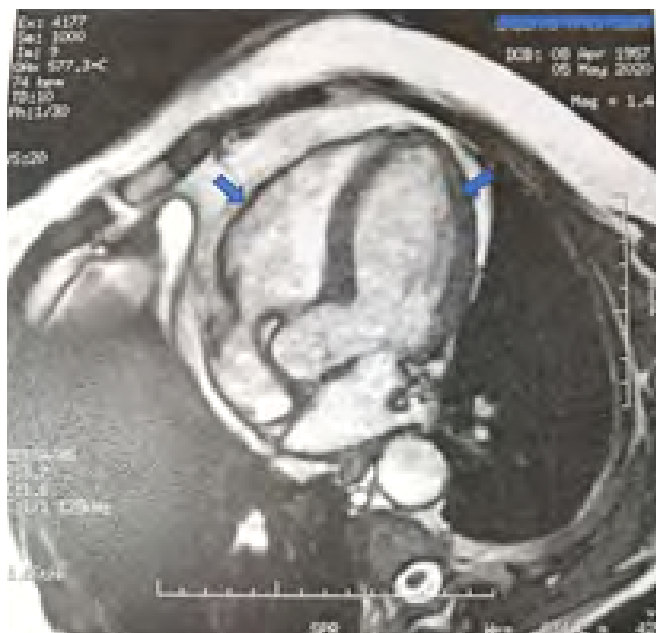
Four-chamber view in MRI enables visualization area of mid myocardial oedema and late gadolinium enhancement of moderate severity in the lateral wall (right arrow). Moreover, mild pericardial effusion was found (left arrow).
